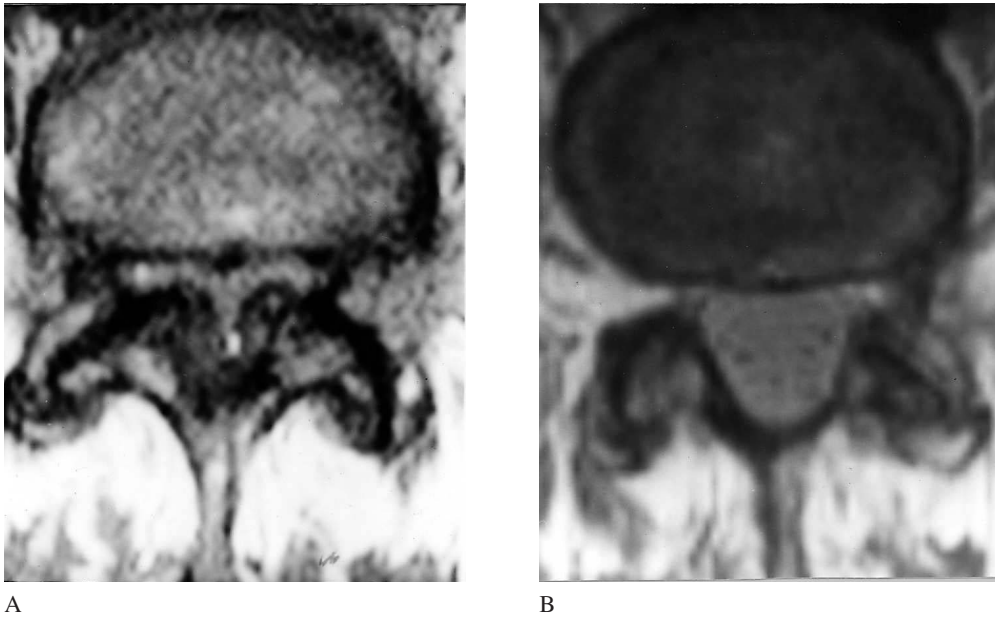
A. Marked spinal stenosis at the L4–L5 level as seen on MRI. B. The same level post-operatively with intact lamina and facet joints.
